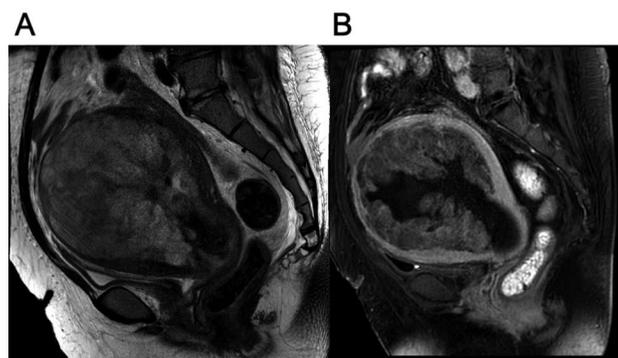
MRI image of the case. A: MRI T2-weighted imaging of pelvis. B: Contrast enhanced MRI image. The tumor has grown in entire endometrial cavity with a size of 120×100 mm.
